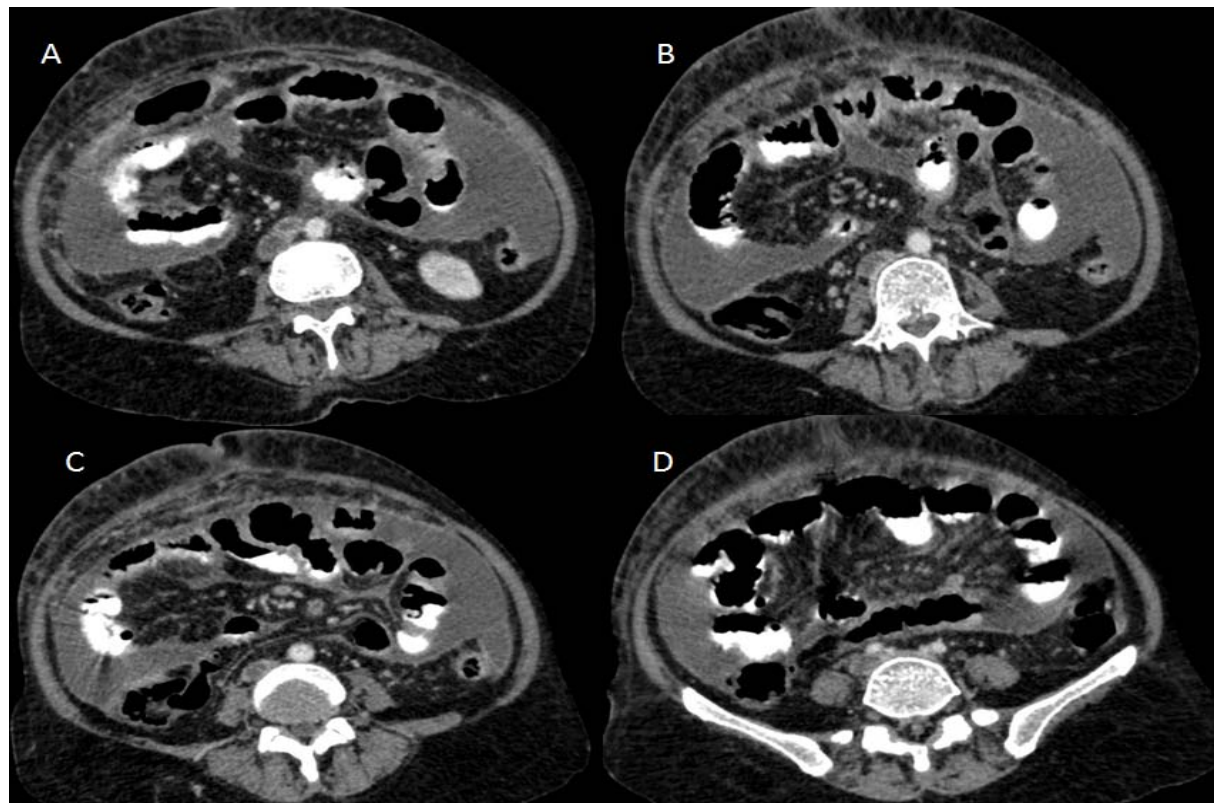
Contrast-enhanced CT scan of the abdomen showing lymph nodes in precaval region (A) with thrombosis in IVC (A-C) extending right common iliac vein (D)
